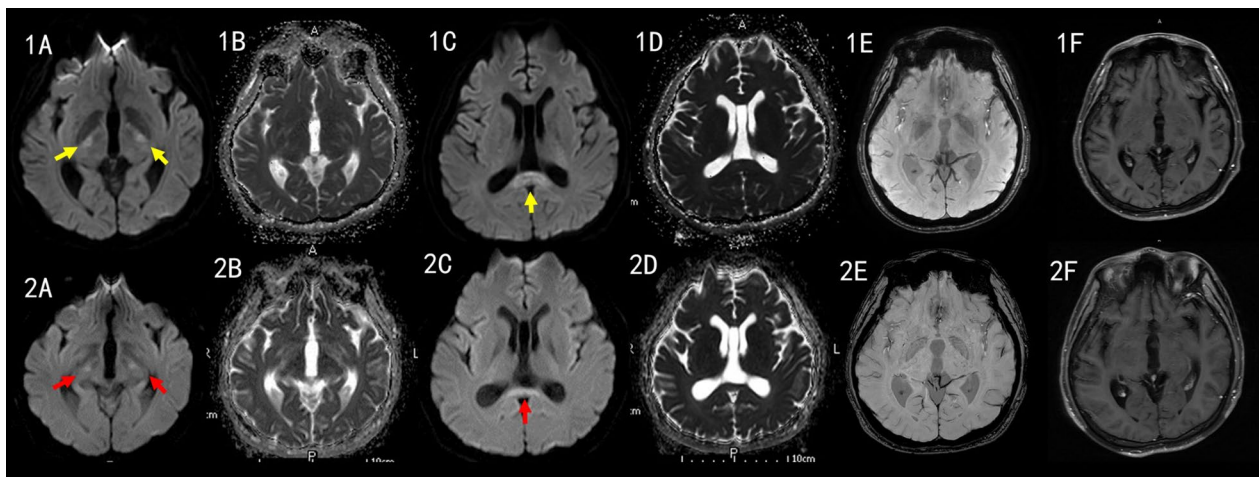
Changes in magnetic resonance imaging over time. Upper row: Findings at 8 weeks. Diffusion-weighted images show symmetrical hyperintensity in the bilateral thalami and splenium of the corpus callosum (1A, 1C, yellow arrows) with no significant enhancement (1F). Apparent diffusion coefficient images showed no typical tricolor patterns on bilateral thalami (1B) and a slightly hyperintense signal in the splenium of the corpus callosum (1D). Susceptibility-weighted imaging showed no evidence of hemorrhage in the thalami (1E). Lower row: findings at the 6-month follow-up. Compared to the 8-week findings, diffusion-weighted images hyperintensity was diminished in the thalami and splenium of the corpus callosum (2A, 2C, red arrows). No changes were seen in apparent diffusion coefficient, susceptibility-weighted imaging, and contrast-enhanced-magnetic resonance images (2B, 2D, 2E, 2F)
